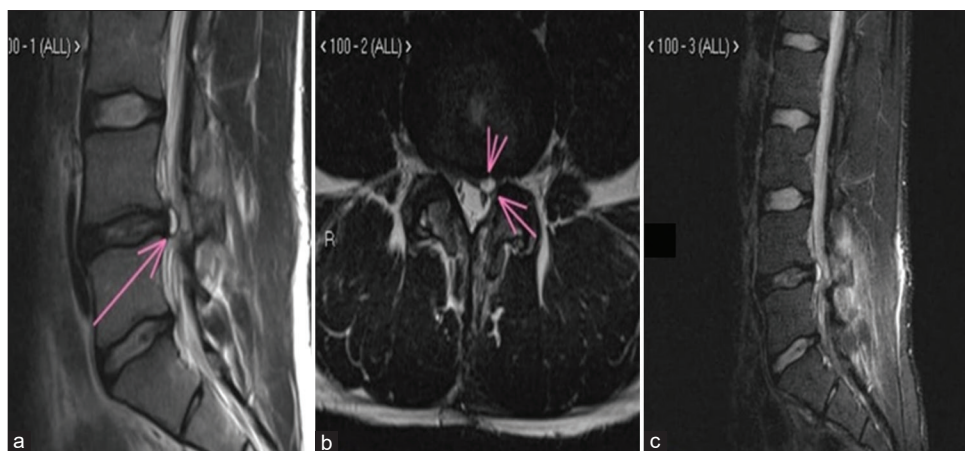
Magnetic resonance imaging spine T2-weighted images show discal cyst at L4–L5 level, (a) sagittal images show discal cyst (see arrow) at L4-5 level, (b) coronal images show discal cyst (see arrow) at L4-5 level, and (c) sagittal images.
